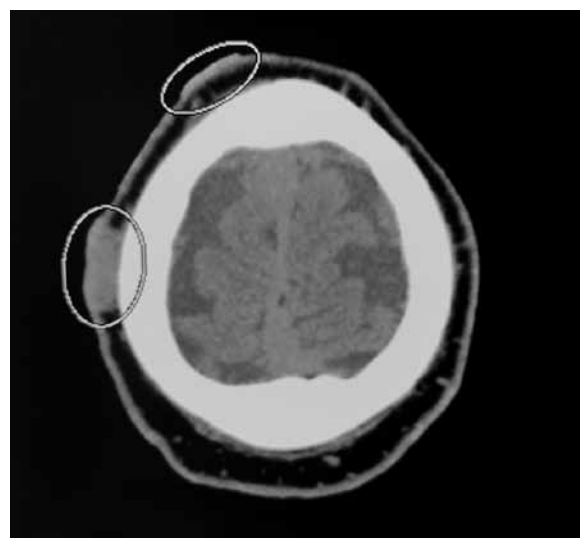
CT scan of the skull. Progression of the process into the soft tissues of the parietal region with destruction of the skull bones
